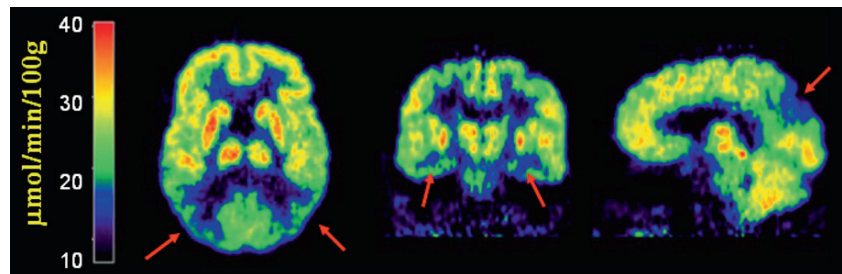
FDG-PET in AD showing typical areas of hypometabolism in posterior cingulate, parietotemporal, and temporomesial cortices (Jacobs et al. 2005)
